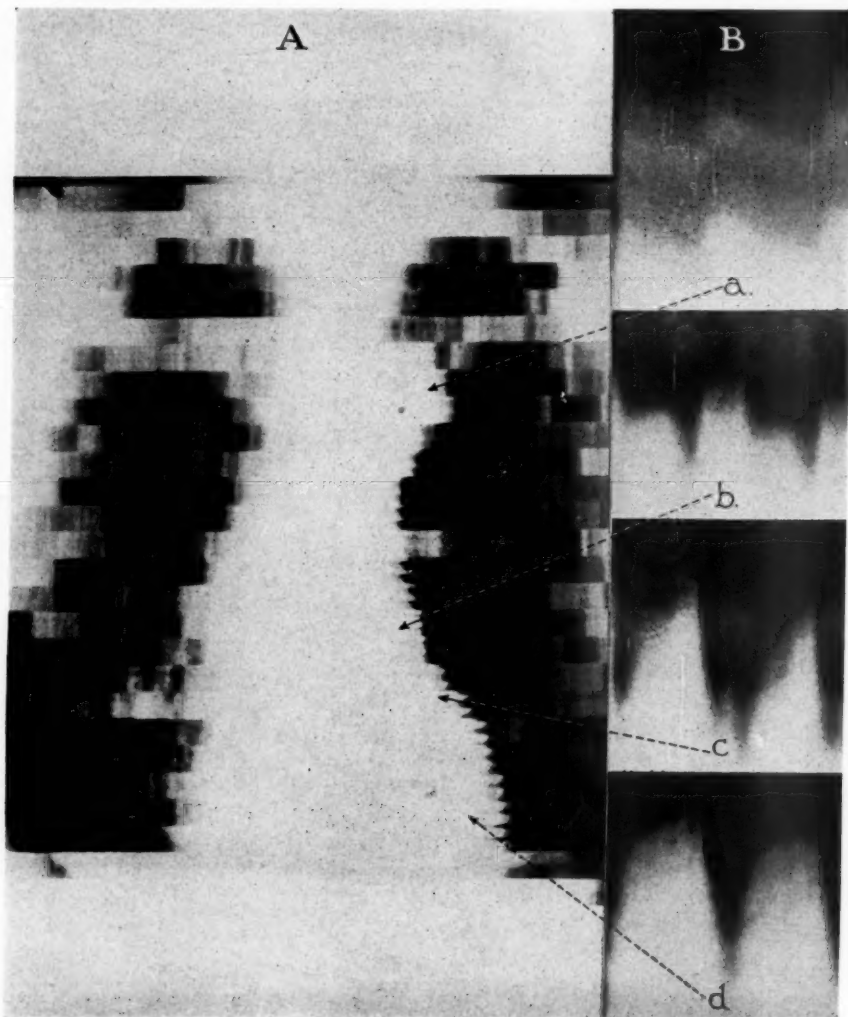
A, Roentgenkymogram, showing paradoxical movement of left ventricle (area c). B, Enlargements of areas from the border of the kymogram arranged to show simultaneous movements: a, aortic arch; b, left auricular appendage (or left auricle); c, left ventricular aneurysm; d, apex of left ventricle. Upward movement on the kymographic enlargements represents cardiac filling. Time relations from left to right.
